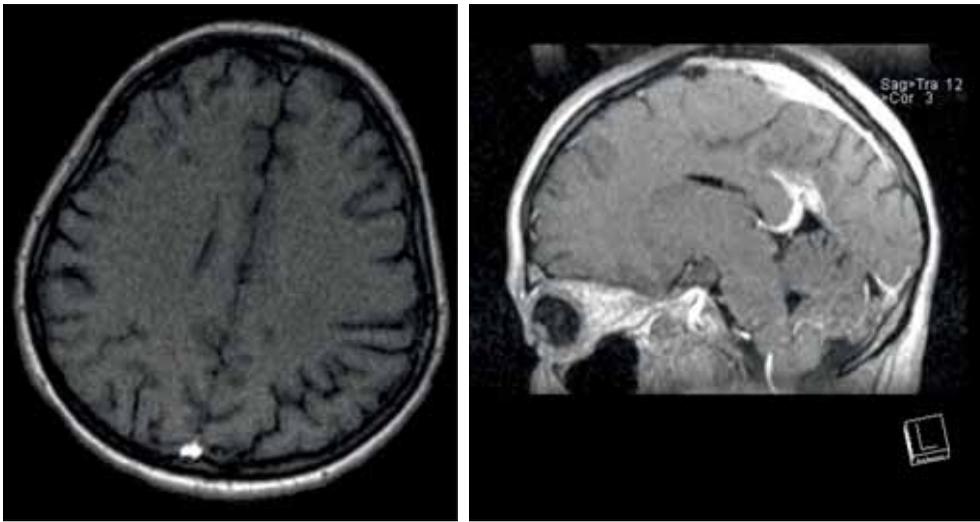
Cerebral MRI – two hypersignal lesions, T2, FLAIR and T1 hyposignal present, with no diffusion restriction, one of 0.9 cm big, situated subcortically and to the right, the other of 0.5 cm being located on the left subcortical parietal side. The lesions described have no gadolinium enhancement. A fine abnormal vascular structure in the right cerebellum is draining the transverse/angyomic venous sinus. There are no pathological iv substance contrast enhancement. There is no evidence of thrombosis of the venous sinuses (a slight left transverse sinus hyperplasia)
